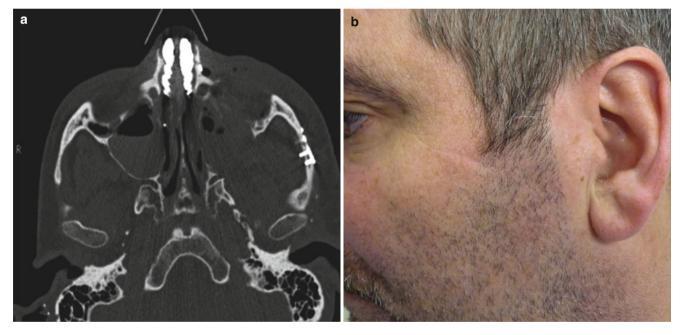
Postoperative CT (a) and wound at 3 months (b)
